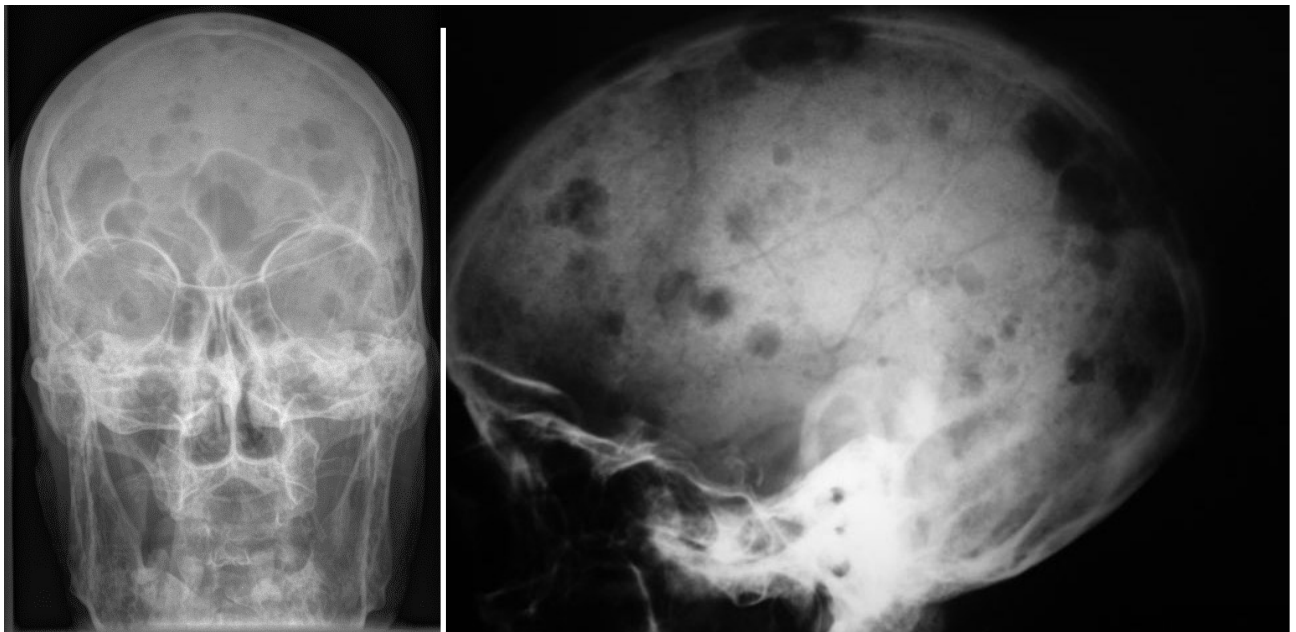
Plain cranial radiograph (anteroposterior, left; lateral, right) of a patient with multiple myeloma showing typical "salt and pepper" lesions.
